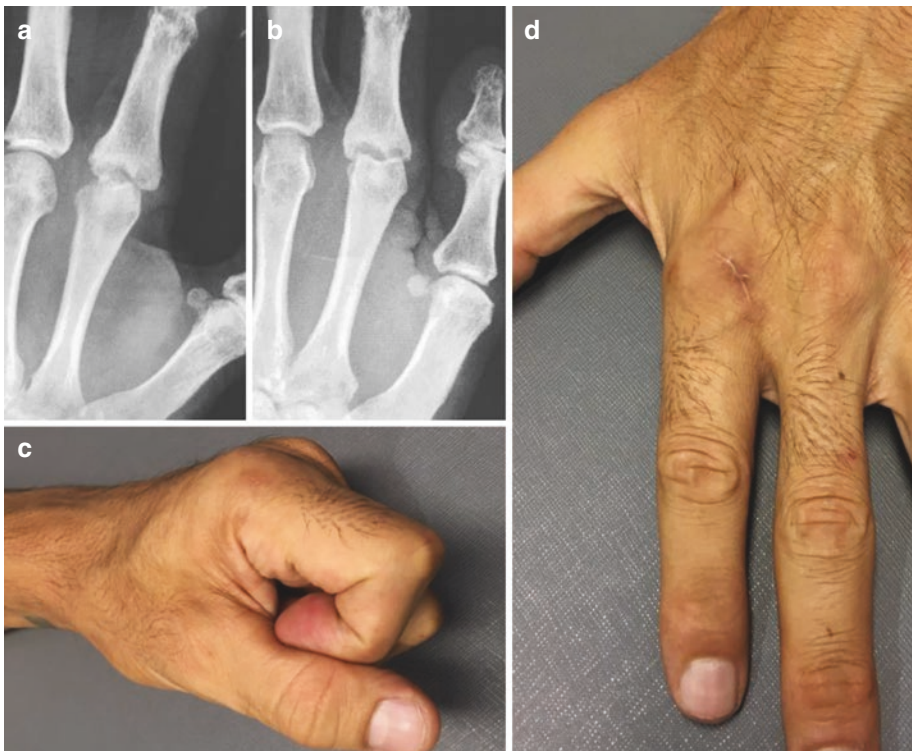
Continuation of the previous case. (a) Preop X-ray. (b) Post-op 6-month X-ray. (c, d) Clinical function on 6-month post-op, showing a small but painless range of motion enough to allow the patient to return to BJJ practicing
